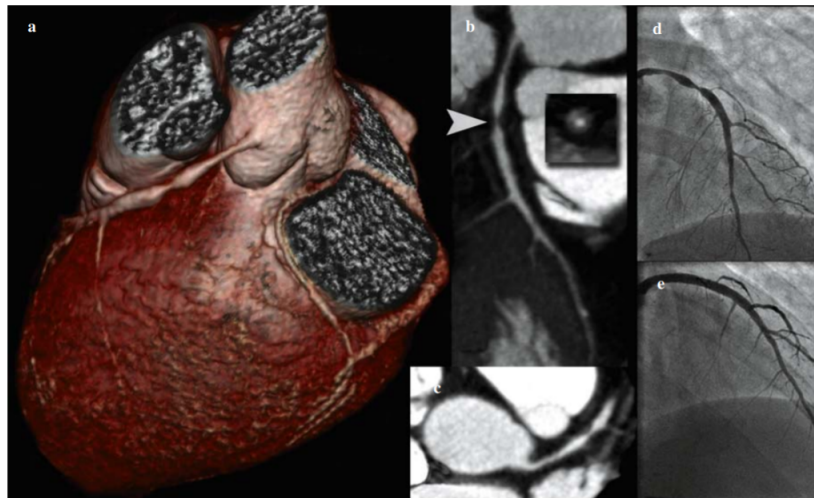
Anterior descending coronary artery lesion with 64-layer CCTA. A patient with an anomaly of origin of the circumflex coronary artery (right coronary sinus and retro-aortic course) and significant stenosis on CT at the proximal tract of the anterior descendant (a; b, arrowhead). The lesion shows peculiar characteristics to the CT, i.e. absence of evident calcifications and presence of positive vascular remodeling (b, box; c). The conventional coronarography performed later (d) confirmed the presence and extent of the lesion that was treated by angioplasty and stenting (e). Figure adapted from [11].
